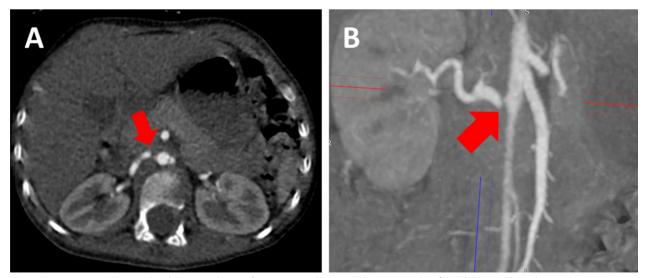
Representative (A) sagittal and (B) coronal image from computed tomography angiography of the abdomen. The red arrow demonstrates high-grade stenosis in the proximal right renal artery
